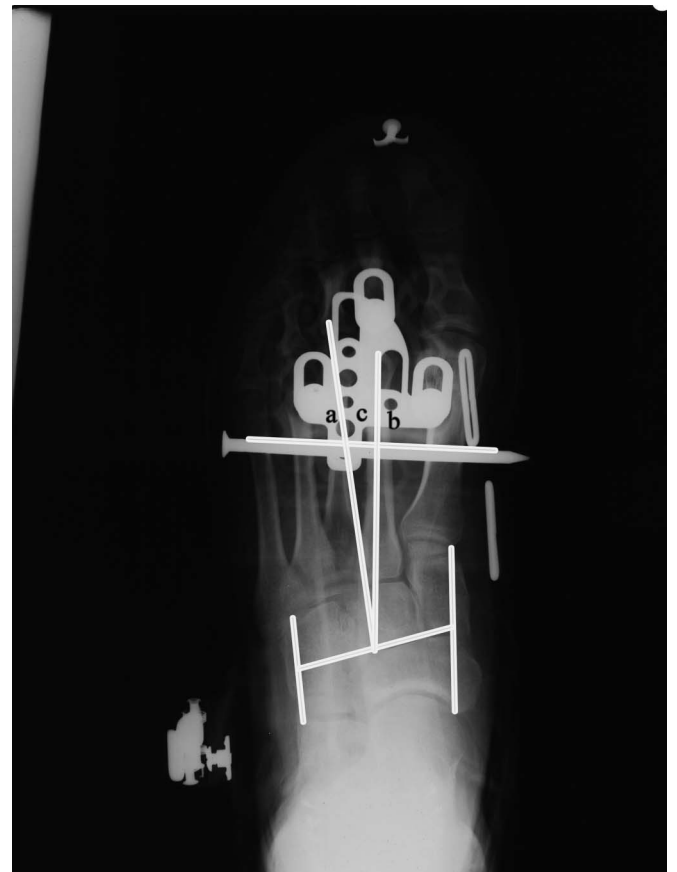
X-ray angles. A, cleat-tarsus minor angle. B, cleat-second metatarsal angle. C, forefoot adductus angle.
